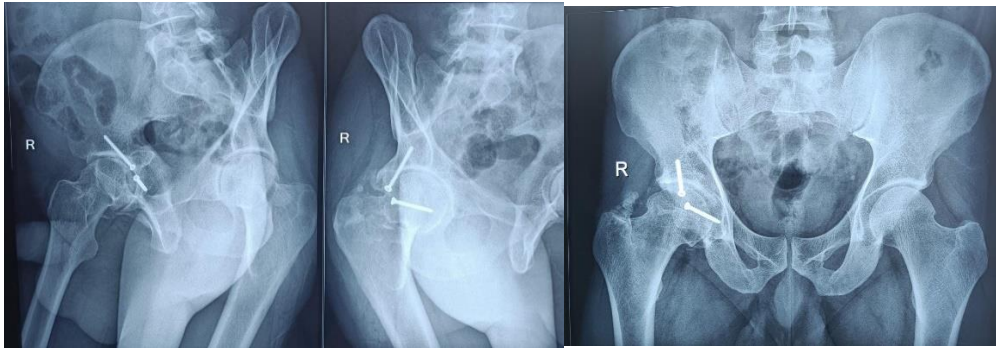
ten years post-op follow-up x-ray images
